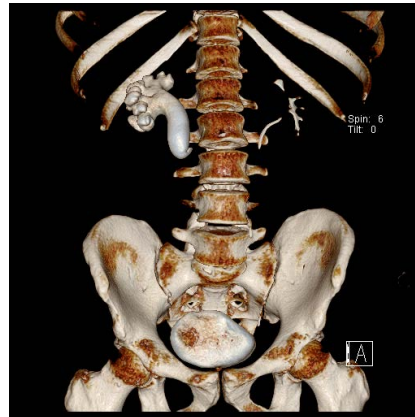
A CT with IV contrast of Case 3 showed mild hydronephrosis and hydroureter of the right kidney.
